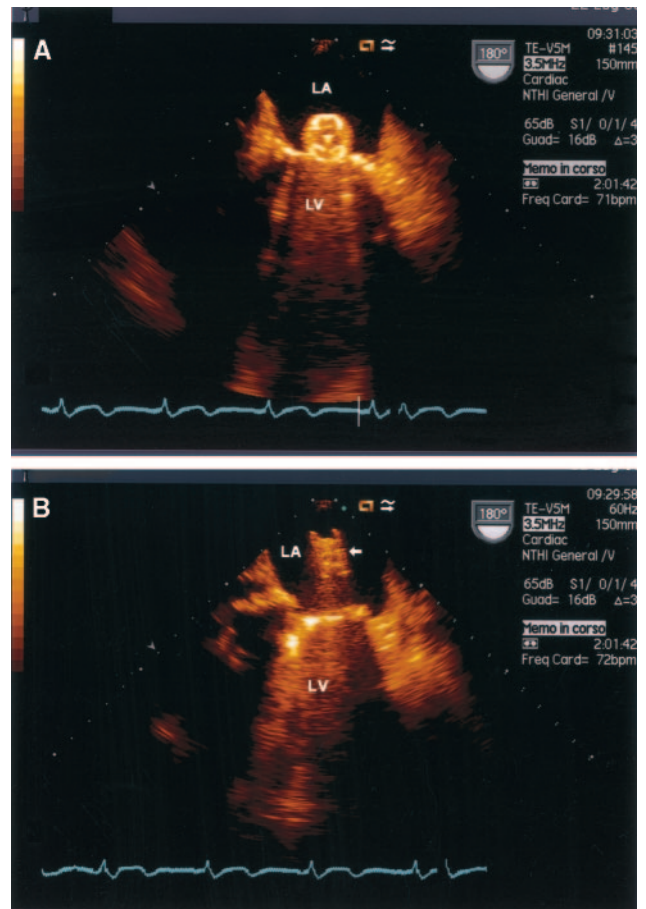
Transesophageal echocardiogram, long-axis view. Two different frames captured during the intraoperative transesophageal echocardiogram examination show the mobilization of the device. The device is seated on the left atrial surface (LA) of the prosthesis (A) and is moved away by the regurgitant jet (B). LV indicates left ventricle.
